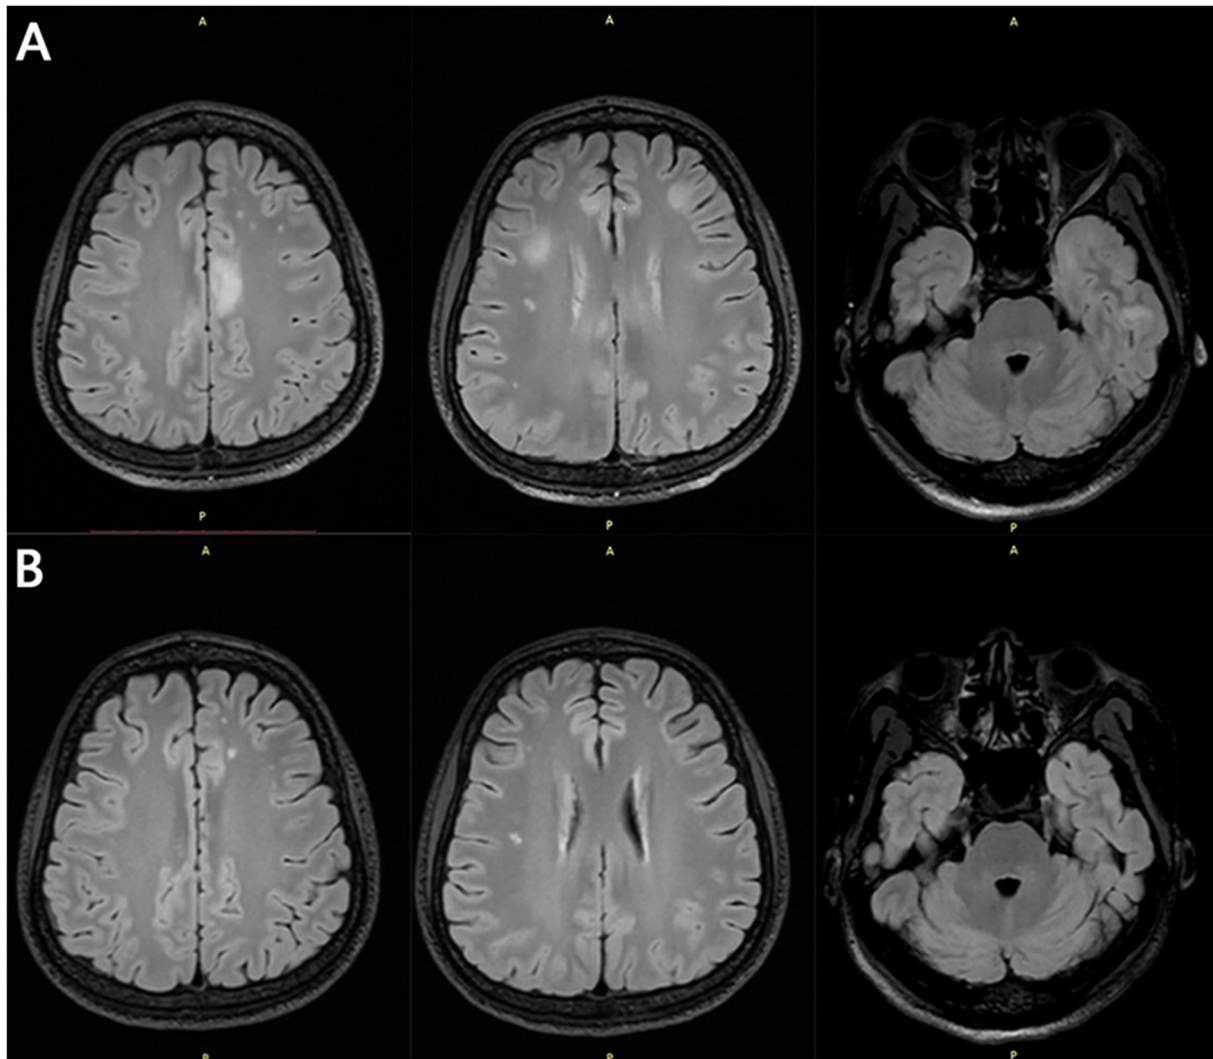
MRI of the head process. All sequences displayed are T2 FLAIR sequences. (A) First admission (September 2024). Cranial MRI without contrast + contrast-enhanced + perfusion + functional imaging: Multiple abnormal signals in the bilateral frontal insula and temporal lobes, and the right occipital lobe; punctate enhancement lesions in the left cingulate gyrus and left temporal lobe. The signals are uniform, with high signal intensity on FLAIR. The borders are poorly defined, with the largest lesion measuring 3.03x1.35 cm. The average signal intensity on FLAIR is 639. No edema or mass effect is observed. An infectious lesion is suspected. Chronic ischemic-hypoxic changes in the deep white matter of both cerebral hemispheres (Fezakas Grade 1). Multiple high signal intensity on FLAIR, appearing as punctate lesions. (B) Second admission for follow-up (October 2024). Multiple punctate lesions in the bilateral frontal and temporal lobes, with high signal intensity on FLAIR. Left cingulate gyrus and temporal lobe with punctate and strip-like enhancement lesions, with some lesions less distinct than previously (September 2024). Bilateral deep white matter hypoxic lesions in the cerebral hemispheres are unchanged from previous findings. FLAIR, fluid-attenuated inversion recovery; A, anterior; P, posterior.
